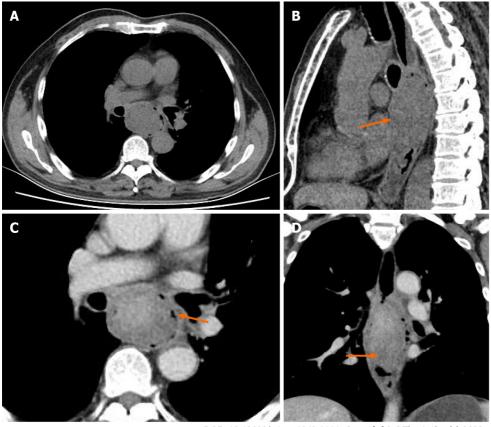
Chest computed tomography images of patient 1. A: Unenhanced computed tomography shows local thickening and luminal narrowing of the esophagus (orange arrow) with an evident fat space between the lesion and surrounding tissues; B: After contrast injection, the mass showed mild homogeneous enhancement with no cystic changes or necrosis.
